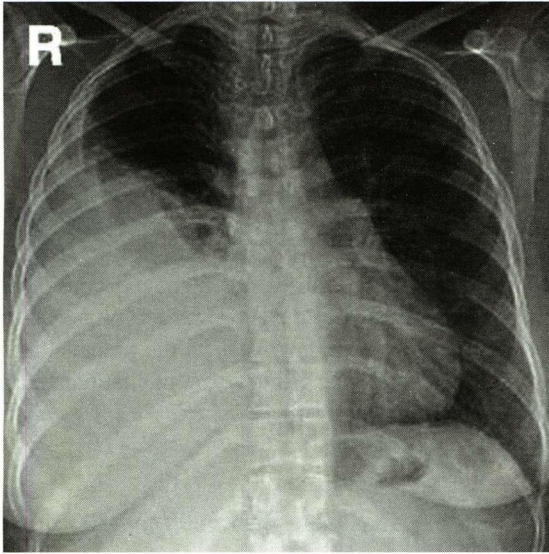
Chest X-ray showing right sided hemothorax with blunting of costophrenic angle
